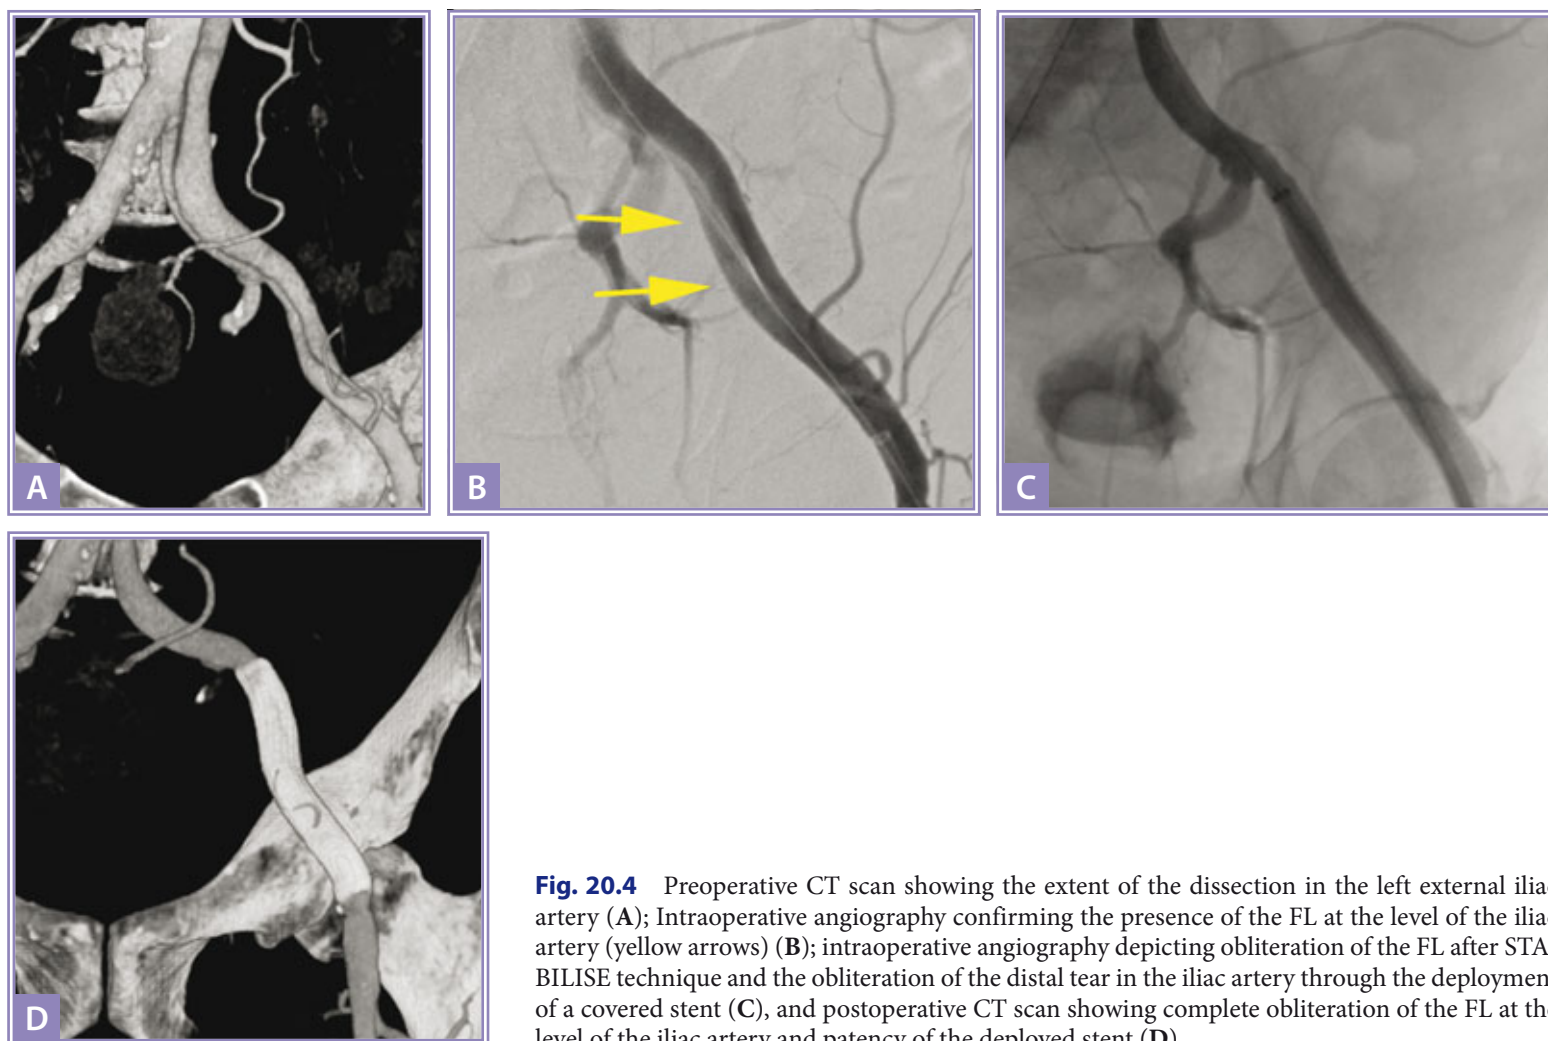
Preoperative CT scan showing the extent of the dissection in the left external iliac artery (A); Intraoperative angiography confirming the presence of the FL at the level of the iliac artery (yellow arrows) (B); intraoperative angiography depicting obliteration of the FL after STA-BILISE technique and the obliteration of the distal tear in the iliac artery through the deployment of a covered stent (C), and postoperative CT scan showing complete obliteration of the FL at the level of the iliac artery and patency of the deployed stent (D).
